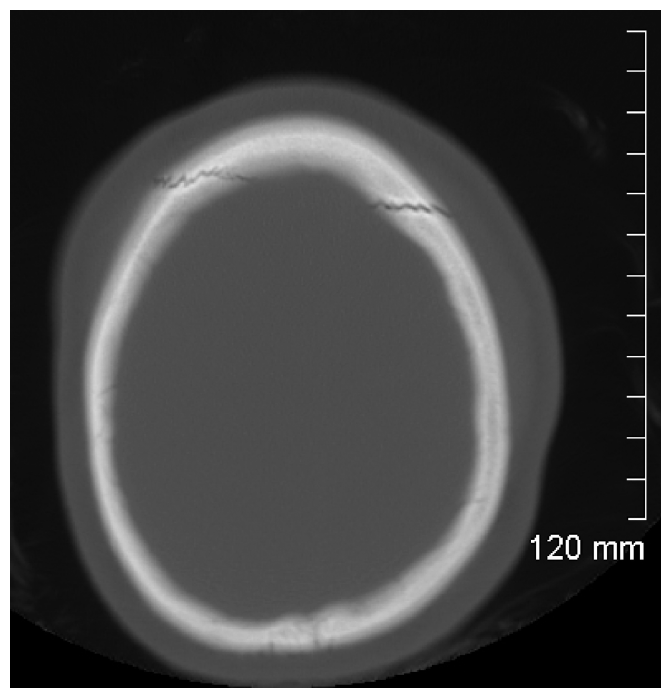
Axial bone-windowed CT scan at time of presentation demonstrates diastasis of the coronal suture.
